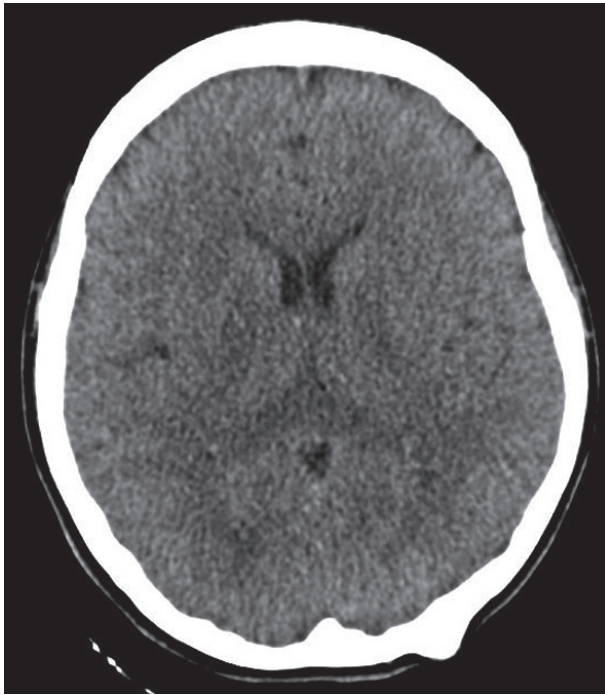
Computed tomography of the patient
